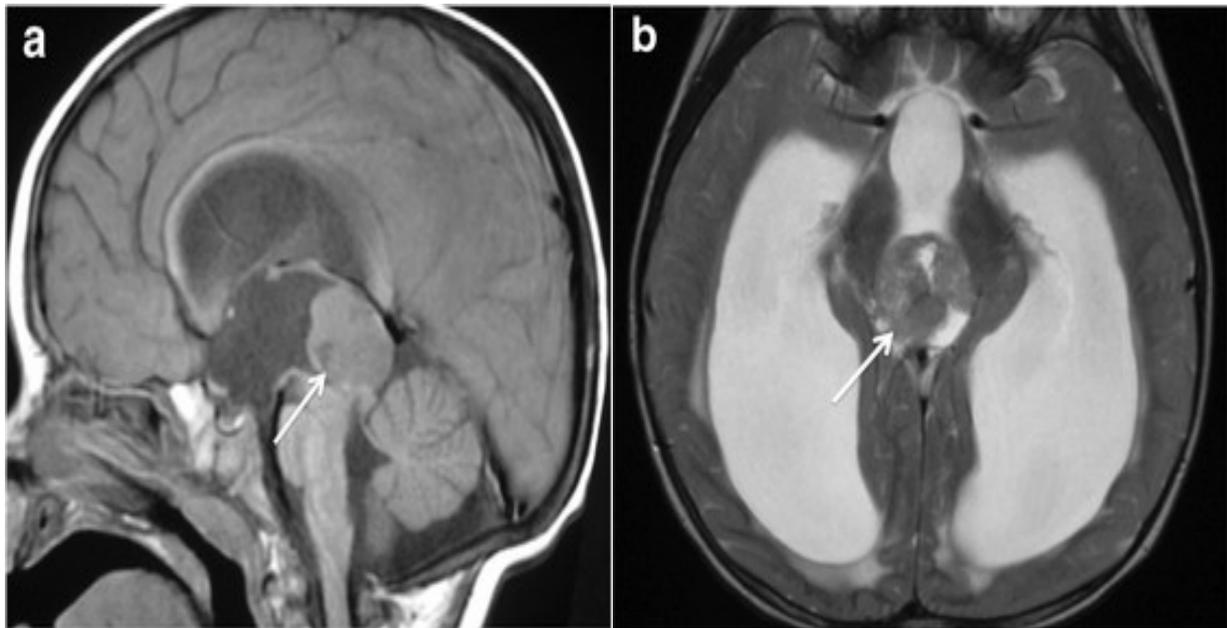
MRI Brain showing tumor arising from the pineal gland (a) Sagittal T1 weighted image (b) Axial T2 weighted image.
